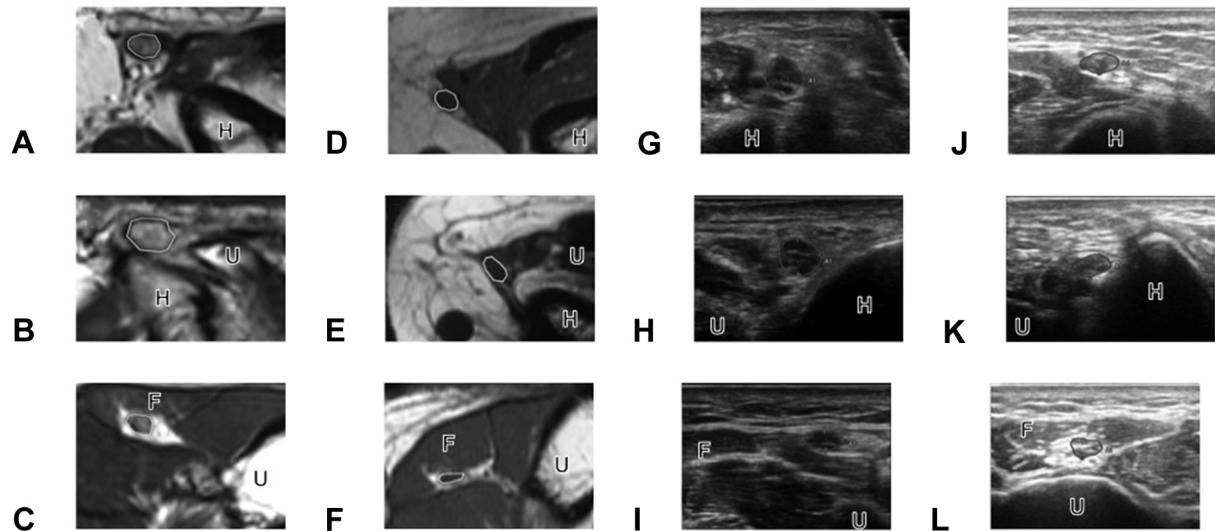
Cross-section of the ulnar nerve at different segment levels by A–F T2-weighted axial MRI and G–L US imaging in patients with UNE (A–C and G–I) and control subjects (D–F and J–L). Images A, D, G, and J were taken at 3 cm proximal to the ME (P3 level). Images B, E, H, and K were taken 1 cm proximal to the ME (P1 level). Images C, F, I, and L were taken 3 cm distal to the ME (D3 level). The UNCASAs in patients with UNE were larger than those in controls at all levels. Images A through C were taken from one patient with UNE, whereas images G through I were obtained from another patient. Images D through F were taken from one control subject, whereas images J through L were obtained from another control subject. H, humerus; U, ulna; F, flexor carpi ulnaris. Measured UNCASAs were 12.6 mm² (A), 18.8 mm² (B), 11.6 mm² (C), 7.3 mm² (D), 8.3 mm² (E), 3.8 mm² (F), 12 mm² (G), 15 mm² (H), 7 mm² (I), 6 mm² (J), 7 mm² (K), and 5 mm² (L) (magnifications $\times 4.00$).
